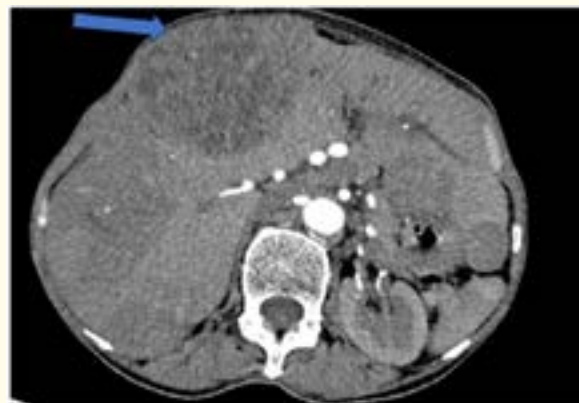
Axial arterial-phase contrast-enhanced CT image showing hepatomegaly with multiple disseminated hepatic lesions demonstrating subtle heterogeneous enhancement. A large segment IVb lesion causes displacement of the right rectus abdominis muscle and bulging of the right flank (Blue arrow).
